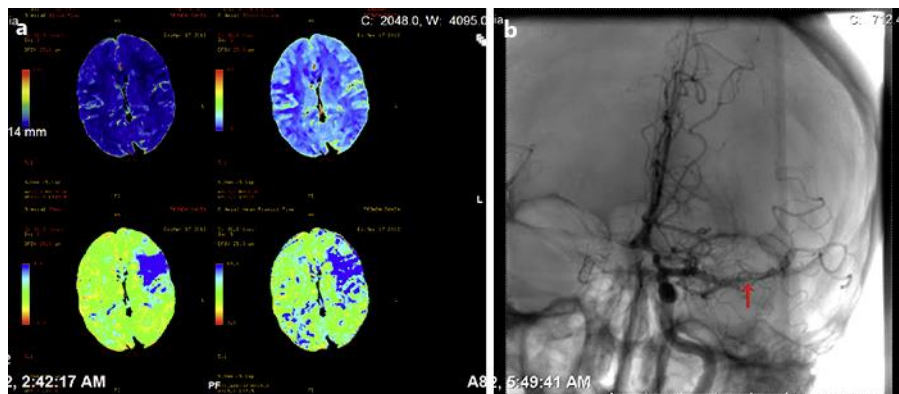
a Hypoperfusion of the left MCA territory. b Perfusion CT imaging showing a decreased perfusion in M1 segment of MCA areas (arrow).
